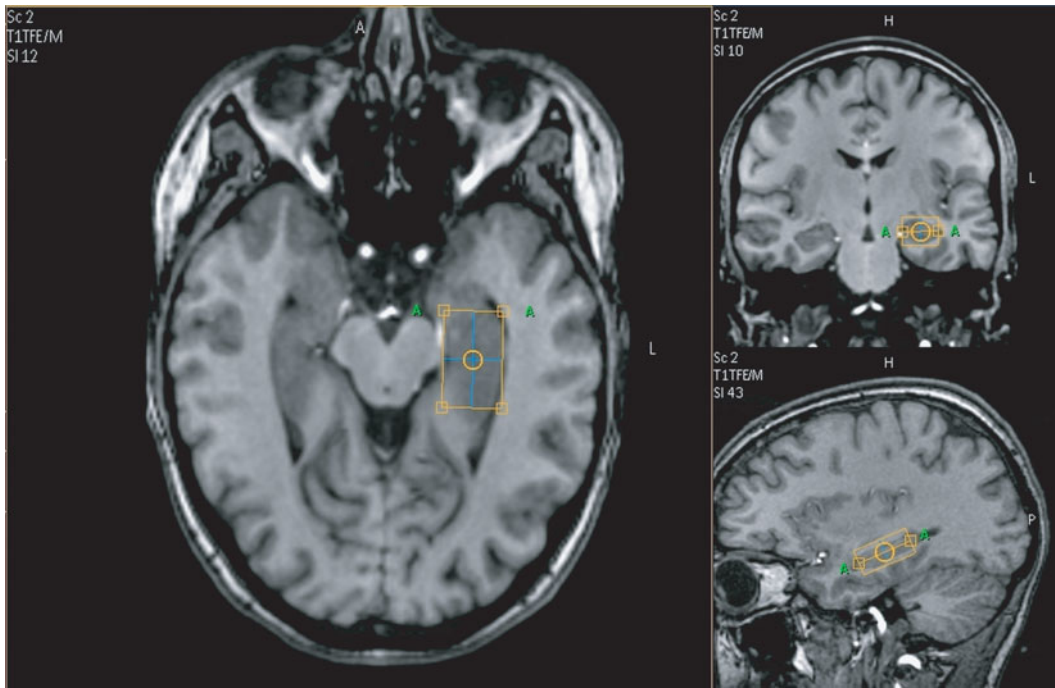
Display of image-guided volume of interest (VOI) selection on axial (angulated parallel to temporal lobe), coronal and sagittal T1w MRI. VOI size in anterior–posterior dimension 28 mm, left–right 17 mm and cranial–caudal 13 mm.
